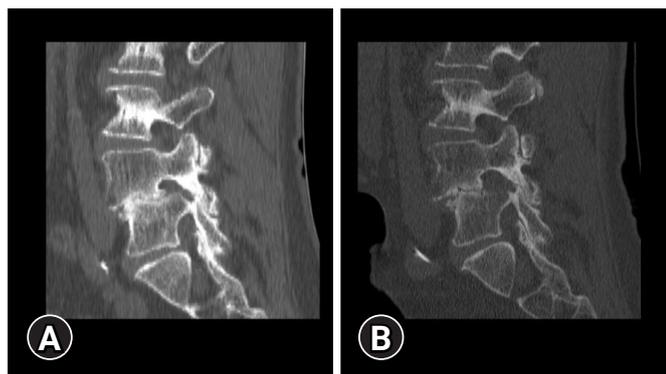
(A) Preoperative CT scan with former foraminal stenosis. (B) Postoperative CT scan showing restitution of cranio-caudal foraminal dimension.
